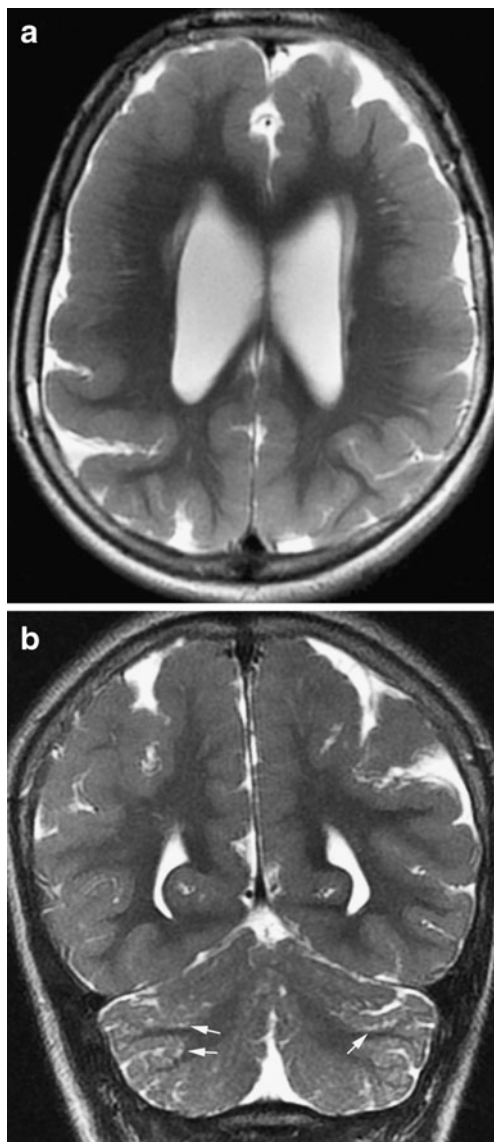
Bilateral frontoparietal polymicrogyria. Axial (a) and coronal (b) T2-weighted images show a different appearance to the cortex, that of multiple radially oriented neuronal components separated by fibroglial stroma. Note the prominent cerebellar fissures and the subcortical cerebellar cysts (arrows)
